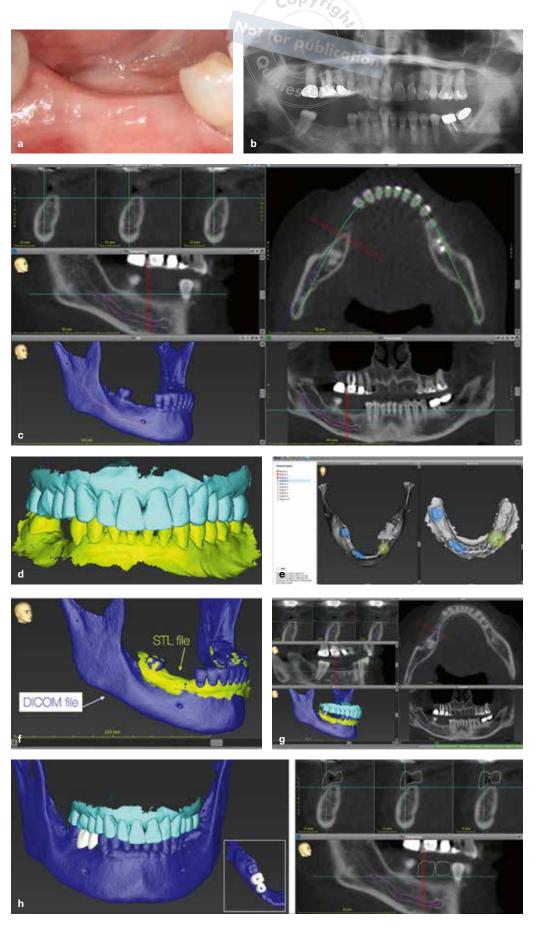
(a) Preoperative clinical presentation of the partially edentulous ridge for missing mandibular right premolar and first molar. (b) Preoperative 2D panoramic radiograph. (c and d) Acquisition of the DICOM and STL files. These two files are the first step for any digital planning for implant therapy. (e to g) Alignment of the DICOM and STL files in the coDiagnostiX implant planning software. A minimum of three points, cross-arch, are chosen on both files to align and superimpose the files accurately. (h) Digital teeth imported in the edentulous site for comprehensive prosthetic treatment planning. Utilizing the STL file of the opposing arch allows the clinician to position the planned teeth in the occlusal relationship prior to planning the implant positions.
